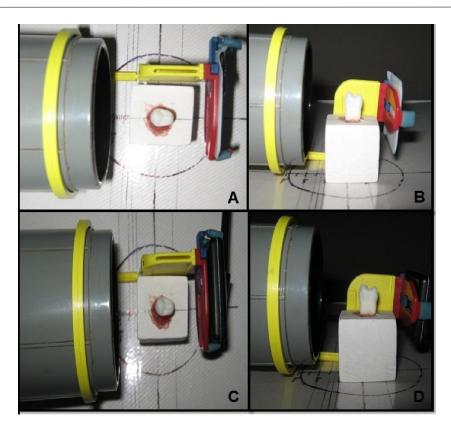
Photograph showing exposure of tooth using intra oral periapical radiographic E-speed film, C and D- Photograph showing exposure of the tooth using RVG sensor
